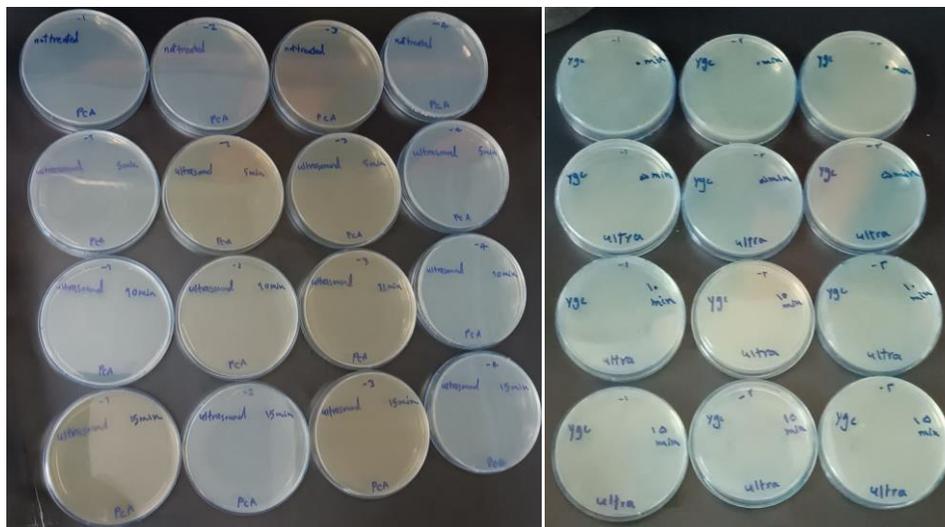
Effect of ultrasonic pretreatment on bacterial growth (PCA medium, left) and mold growth (YGC medium, right) on microbial culture plates after incubation
